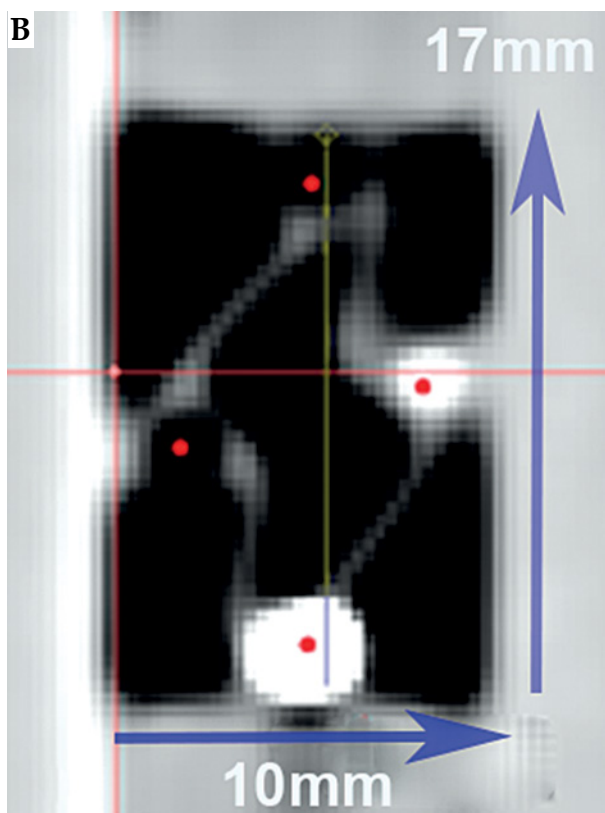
A) Contracted corpus; B) CT image of expanded corpus
